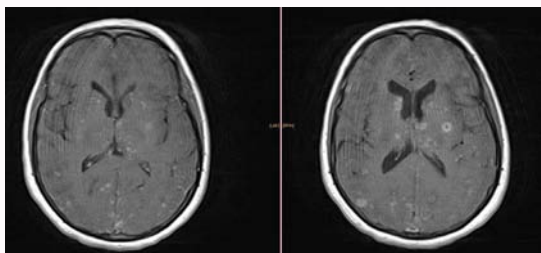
T2 weighted Brain MRI sections showing multiple hyperintense nodular lesions in different cortical and sub-cortical areas.
